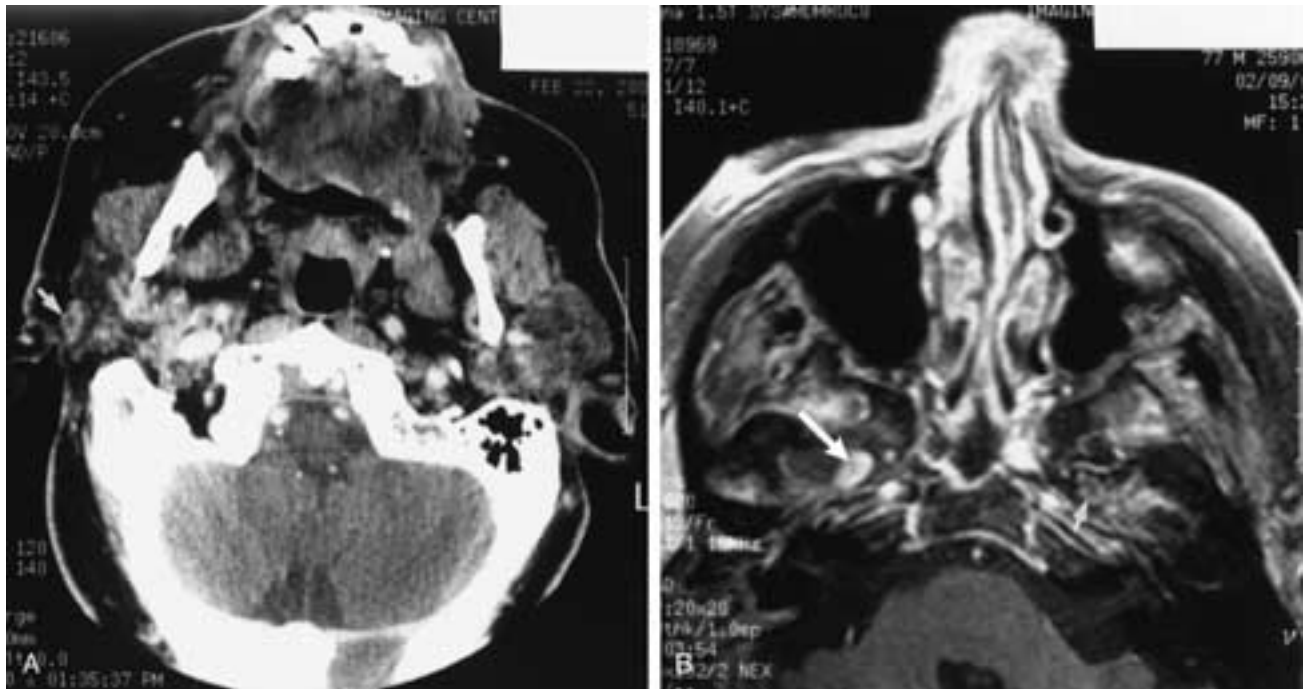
Recurrent preauricular cutaneous squamous cell carcinoma with parotid invasion and PNS along the auriculotemporal branch of V_3 . A, Axial contrast-enhanced CT scan shows tumor in the superficial lobe of the right parotid gland (*arrow*). There was no bulky tumor extending into the masticator space. B, Axial contrast-enhanced, fat-suppressed T1-weighted image shows excessive enhancement representing tumor in the foramen ovale (*large arrow*). From the parotid gland, the only way tumor could spread to the foramen ovale is along the auriculotemporal nerve. Note that there is a small amount of normal enhancement in the normal left foramen ovale (*small arrow*).
